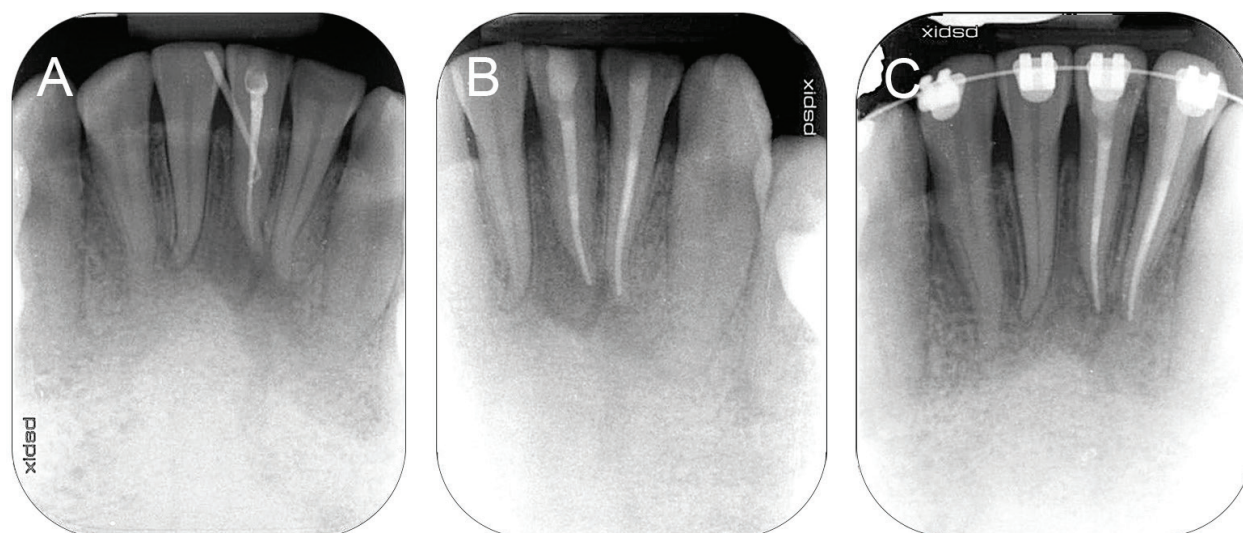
Endodontic lesion managed by endodontic retreatment. (A) Periapical radiograph of previously root treated tooth 31 exhibiting a large periapical lesion and infection draining through buccal gingival sulcus; (B) retreatment of 31 and RCT of a non-vital 32 completed; (C) radiograph of 31 and 32 showing bone fill 6 months post treatment.
